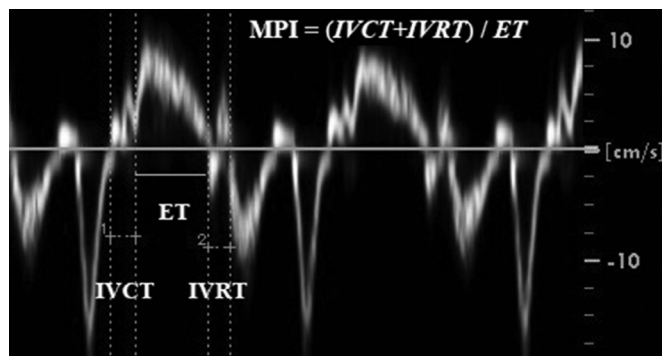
Tissue Doppler-derived measurements of MPI obtained from the lateral tricuspid annulus. ET indicates ejection time; IVCT, isovolumic contraction time; IVRT, isovolumic relaxation time; MPI, myocardial performance index.
